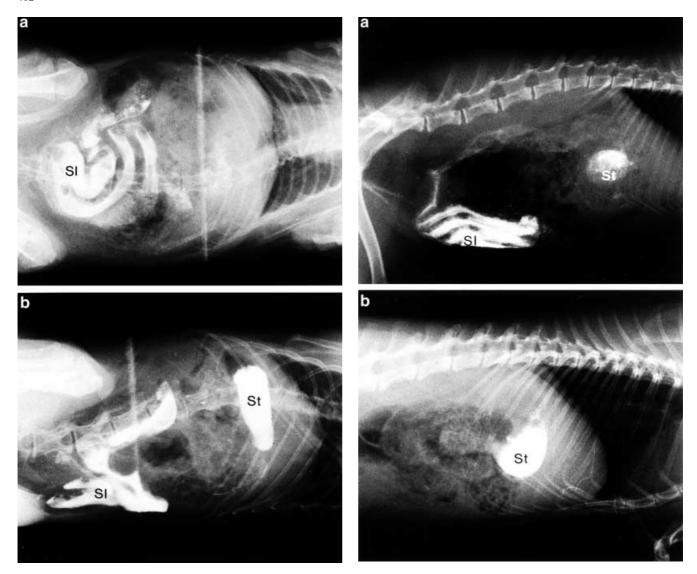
Left lateral recumbent radiograph of bilbies (a) maintained on mealworms, and (b) maintained on seeds, 10–15 min after dosing with barium sulphate. *St* stomach, *SI* small intestine
